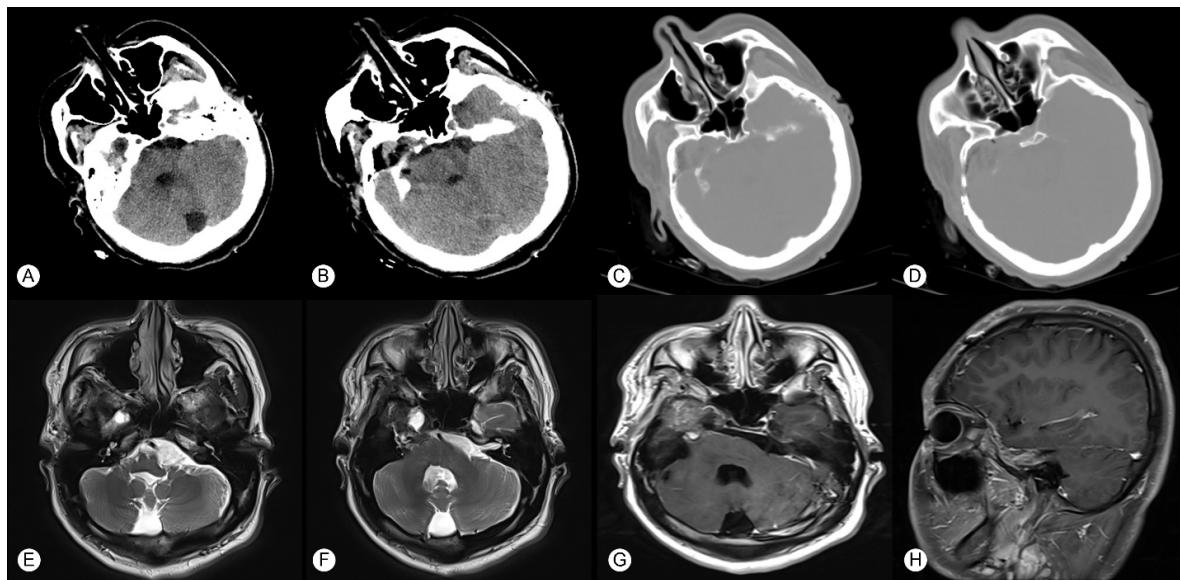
The postoperative imaging data of Case 2. (A)~(D). Brain CT scan and bone window. (E)~(H). MRI and its enhancement scan
